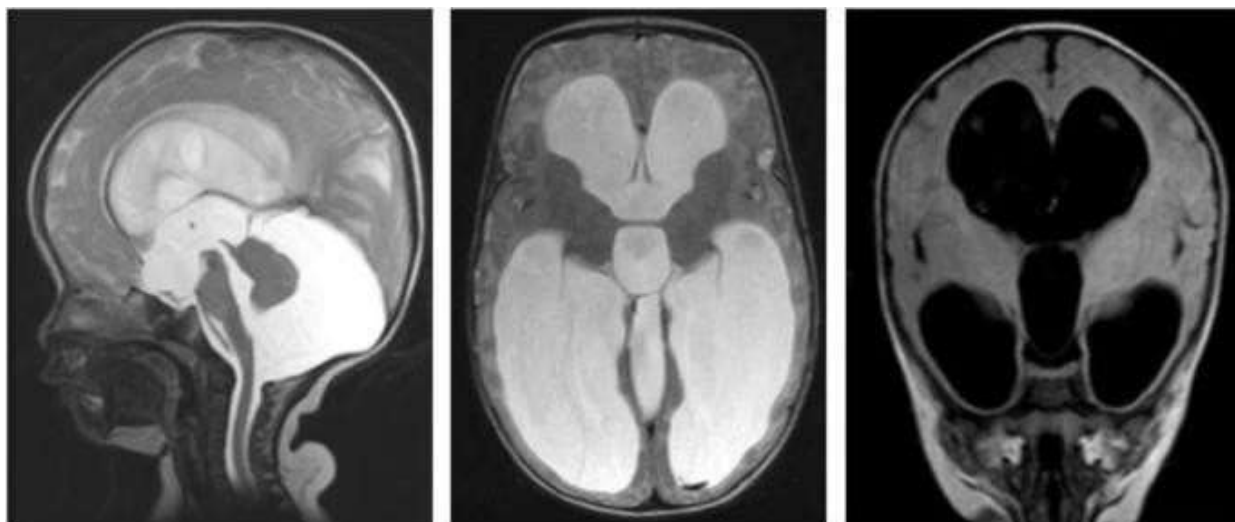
Brain MRI of a 4 months old male infant. Clinical indication: Hydrocephalus. Description: Sagittal T2, Axial fast spin echo (FSE T2), and Coronal Fluid attenuation inversion recovery (FLAIR) sequences performed on a 1.5 T MR scanner revealed grossly dilated lateral and third ventricles with posterior fossa cyst communicating with the fourth ventricle inferiorly and hypoplastic cerebellar vermis. The cerebellar hemispheres are also small and displaced anteriorly. The surrounding cerebral parenchyma is thinned out. The major intracranial arterial and venous flow-voids are patent. The visualized portions of the paranasal sinuses and orbits are unremarkable. IMPRESSION: Hydrocephalus with posterior fossa cyst and cerebellar vermis hypoplasia likely Dandy-Walker malformation (Blein Mulugeta, et al., 2022).
